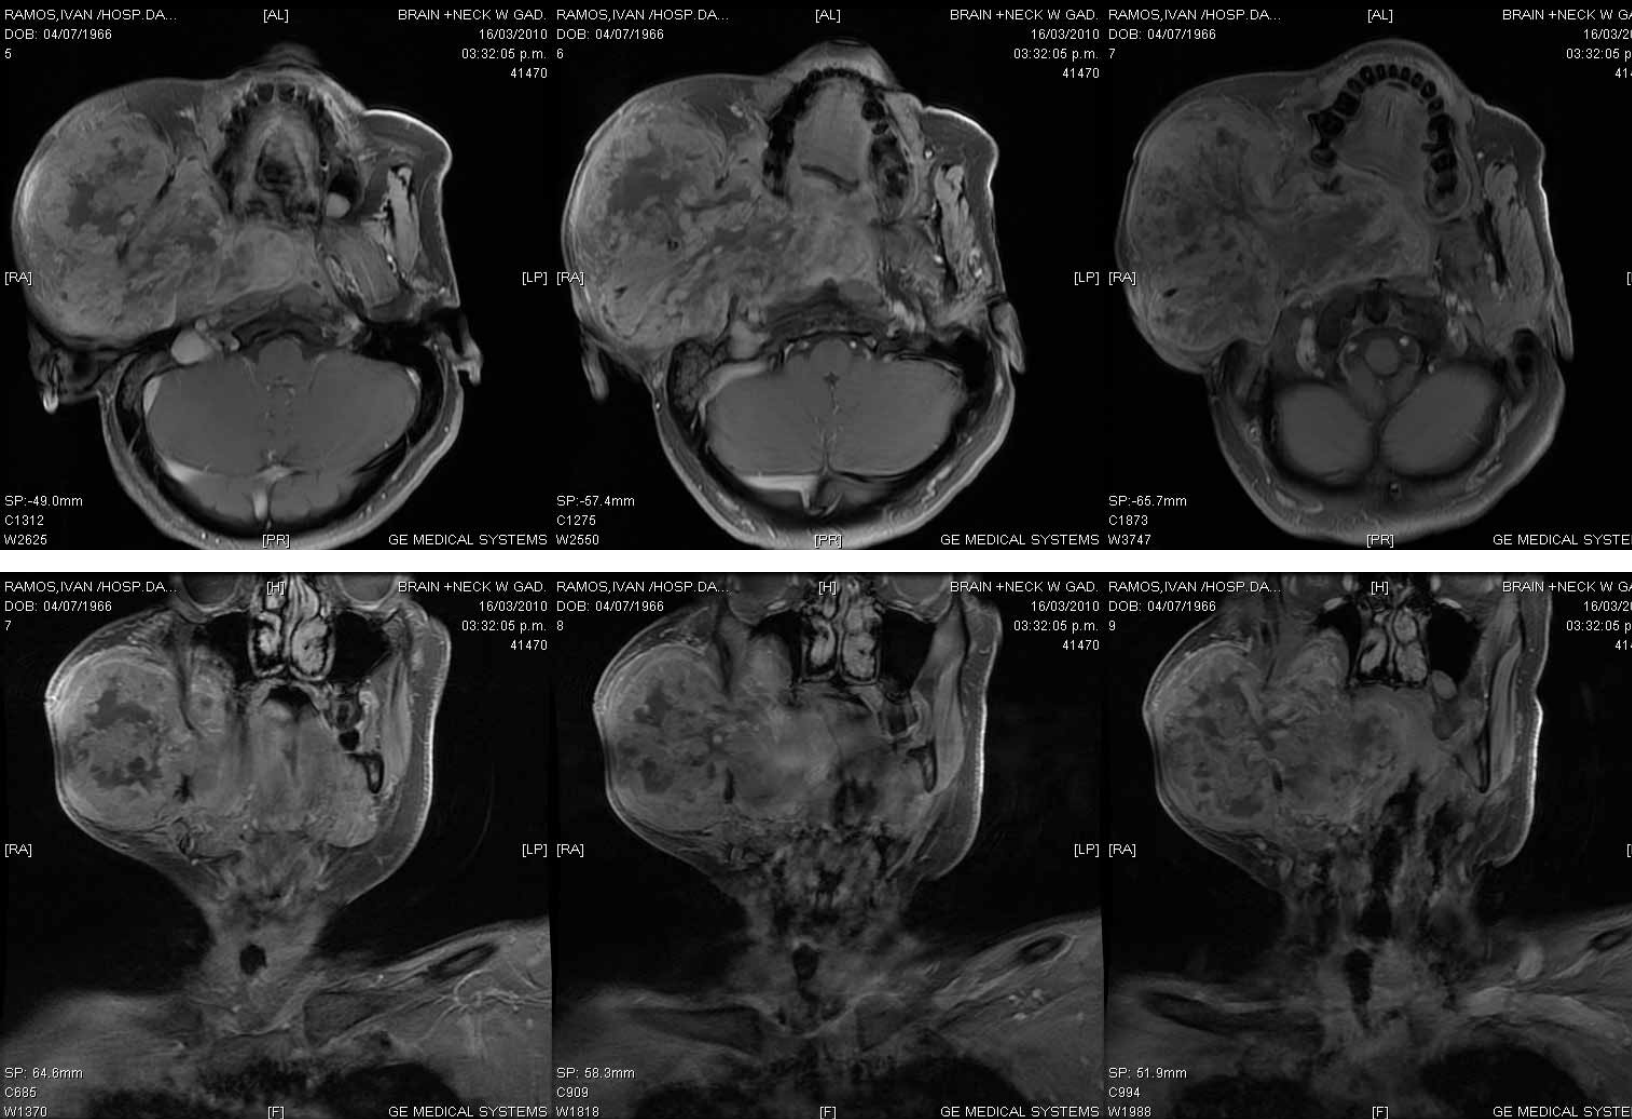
Brain and Neck MRI with contrast (AX T1 SPGR and COR T1 SPGR) images demonstrating a homogeneous, large soft tissue mass, localized in the right parapharyngeal space with involvement of the parotid gland, destruction of the right mandible, lateral wall of the maxillary sinus, with complete occlusion of the oropharyngeal and nasopharyngeal airway.
